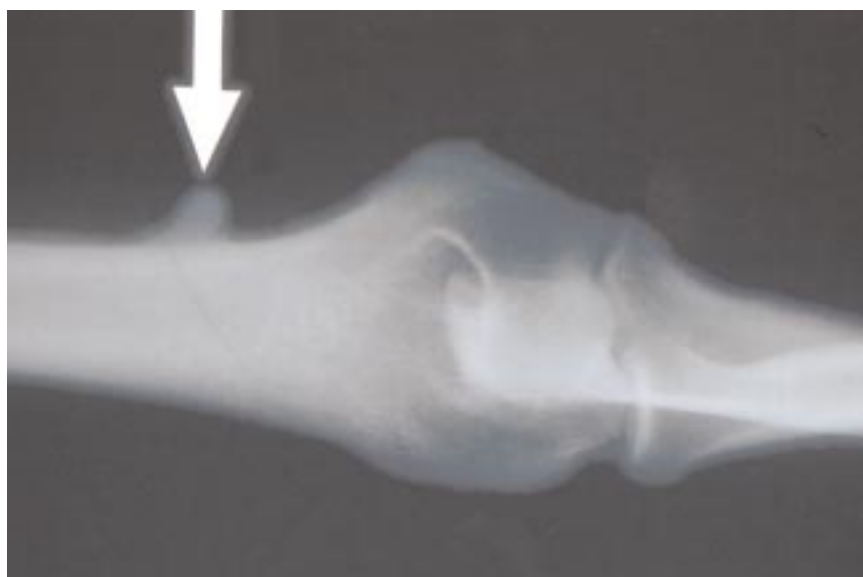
Anteroposterior radiograph shows a characteristic supracondyloid process (arrow). When this appearance is seen in a symptomatic patient, removal of the supracondyloid process and the associated ligament of Struthers should be considered.
